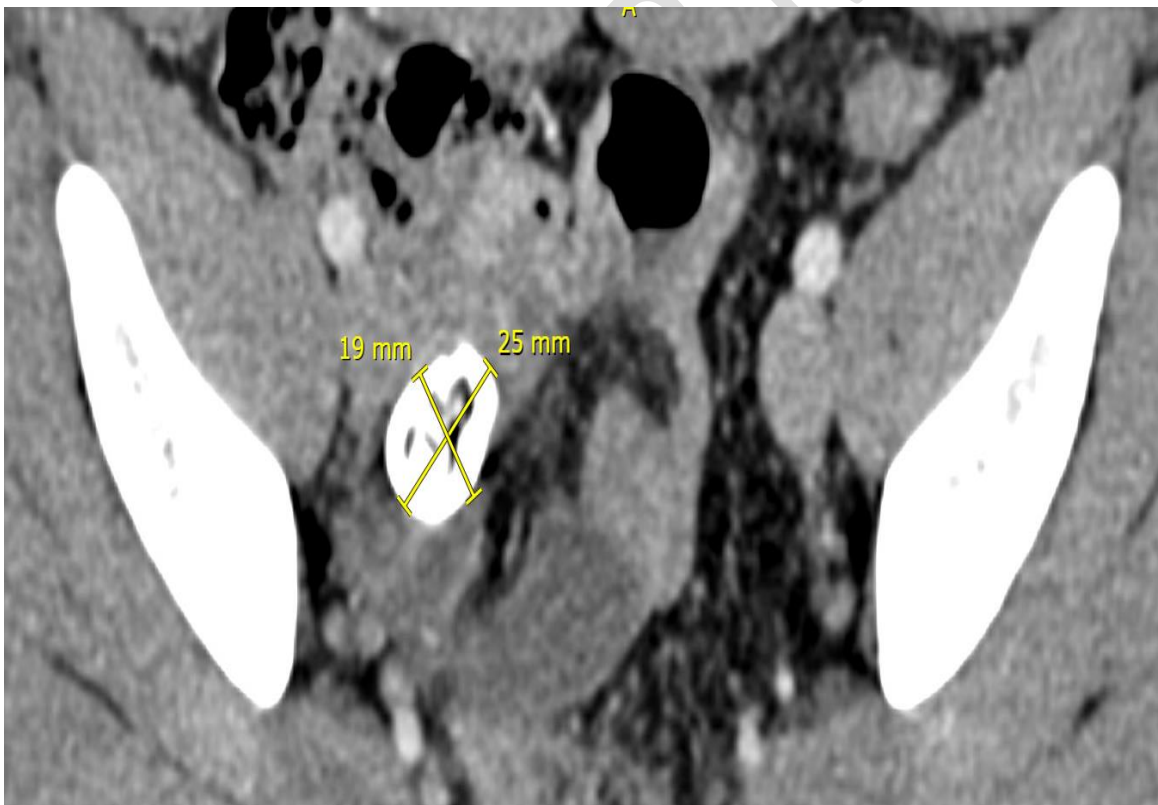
the CT of the abdomen hyperdense calcification in the pelvis.
